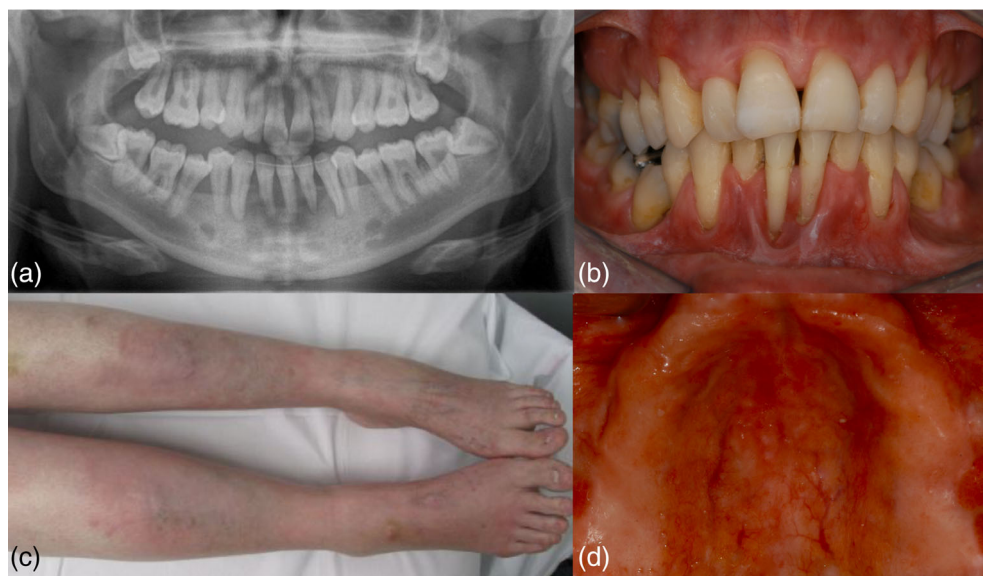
Main characteristics of adult individuals with periodontal Ehlers-Danlos syndrome. Major criteria are (a) early onset periodontitis (panoramic X-ray of a woman aged 22 years), (b) lack of attached gingiva and (c) pretibial plaque. Picture (d) shows increased visibility of vessels on the palate due to thin, translucent palatal gingiva in pEDS. [Colour figure can be viewed at wileyonlinelibrary.com]
